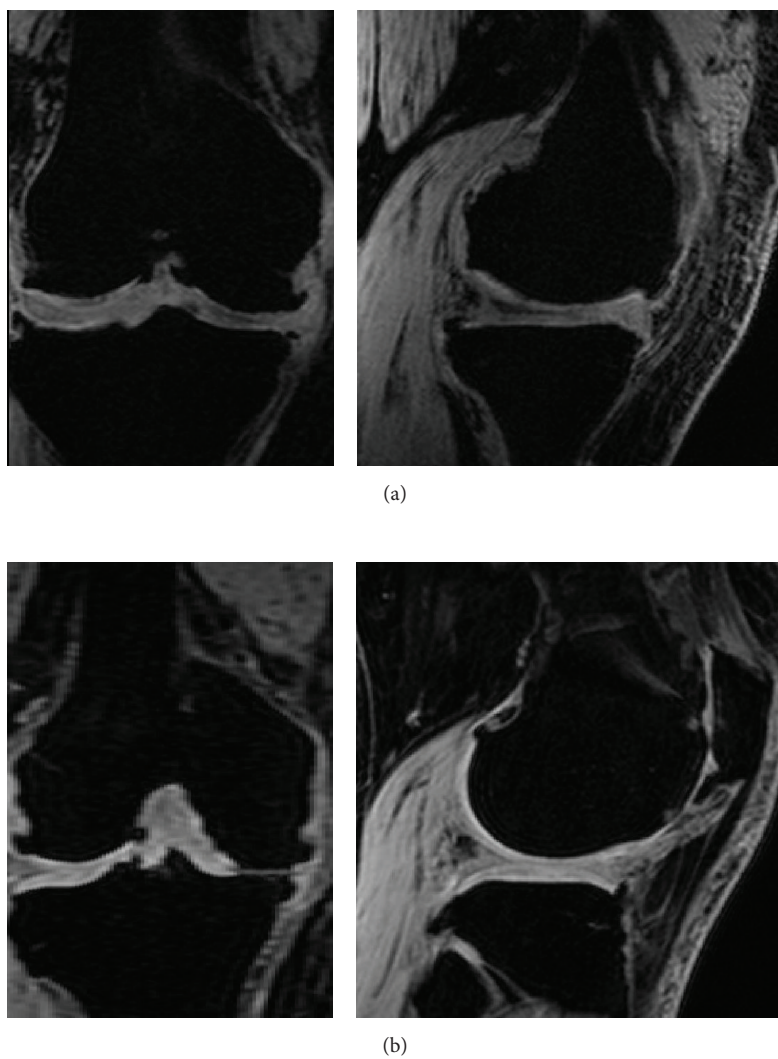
MRI images categorized based on the quality of images: (a) with motion artifacts; (b) without motion artifacts.
